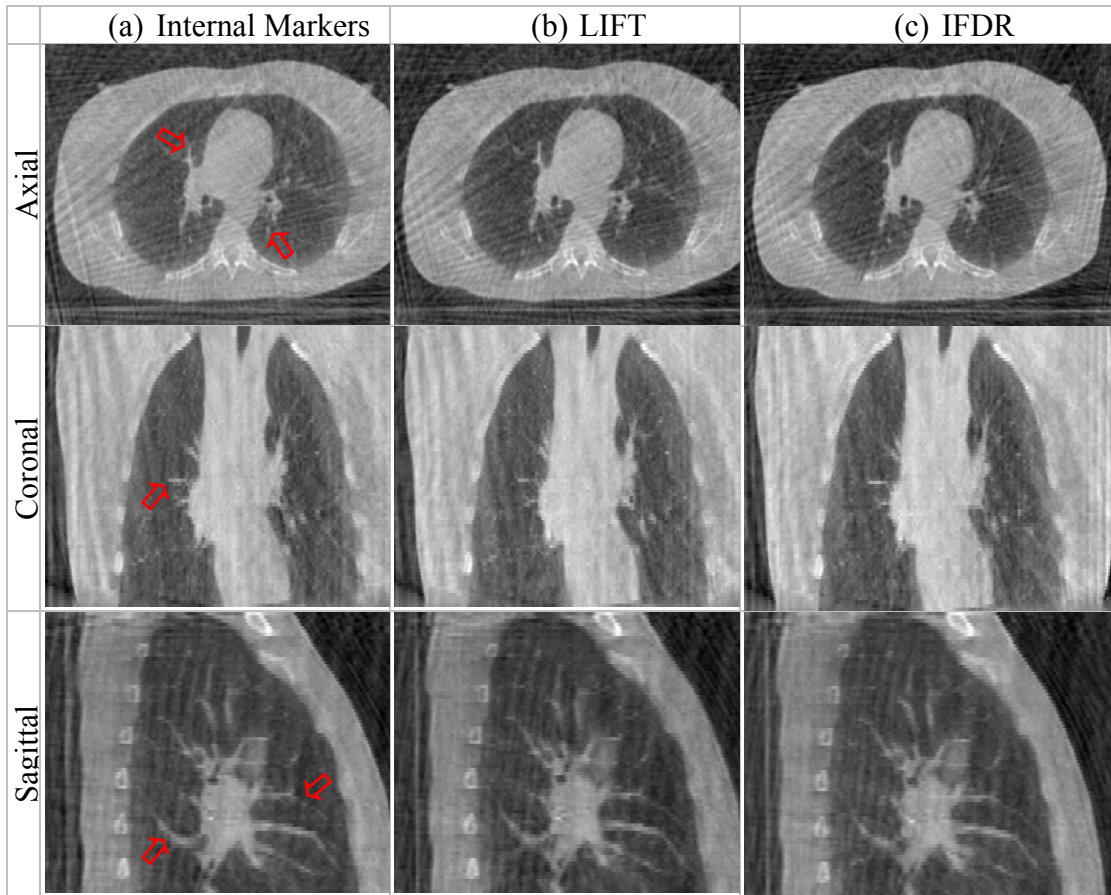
4D-CBCT Reconstruction from projection of Patient 2 sorted using different methods
